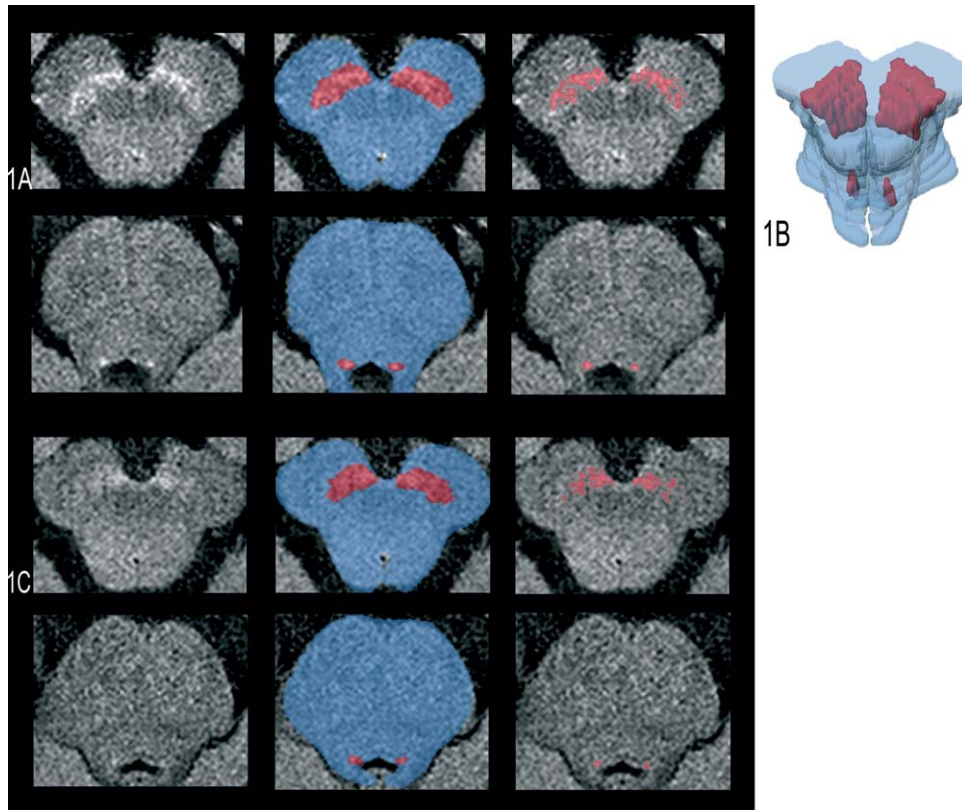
NM-MRI showing the automatically segmented regions of interest (ROIs). SNc and LC of a healthy subject (A). Three-dimensional surface rendering corresponding to automated segmentation of the bilateral SNc and LC (B). NM-MRI of a patient with iPD with 4 years of motor symptom duration (C). NM-MR images of the SNc and LC (first column). ROIs detected in the automated segmentation with the brainstem background area shown in blue (second column). Hyperintense pixels of the SNc and LC above the threshold (third column).
